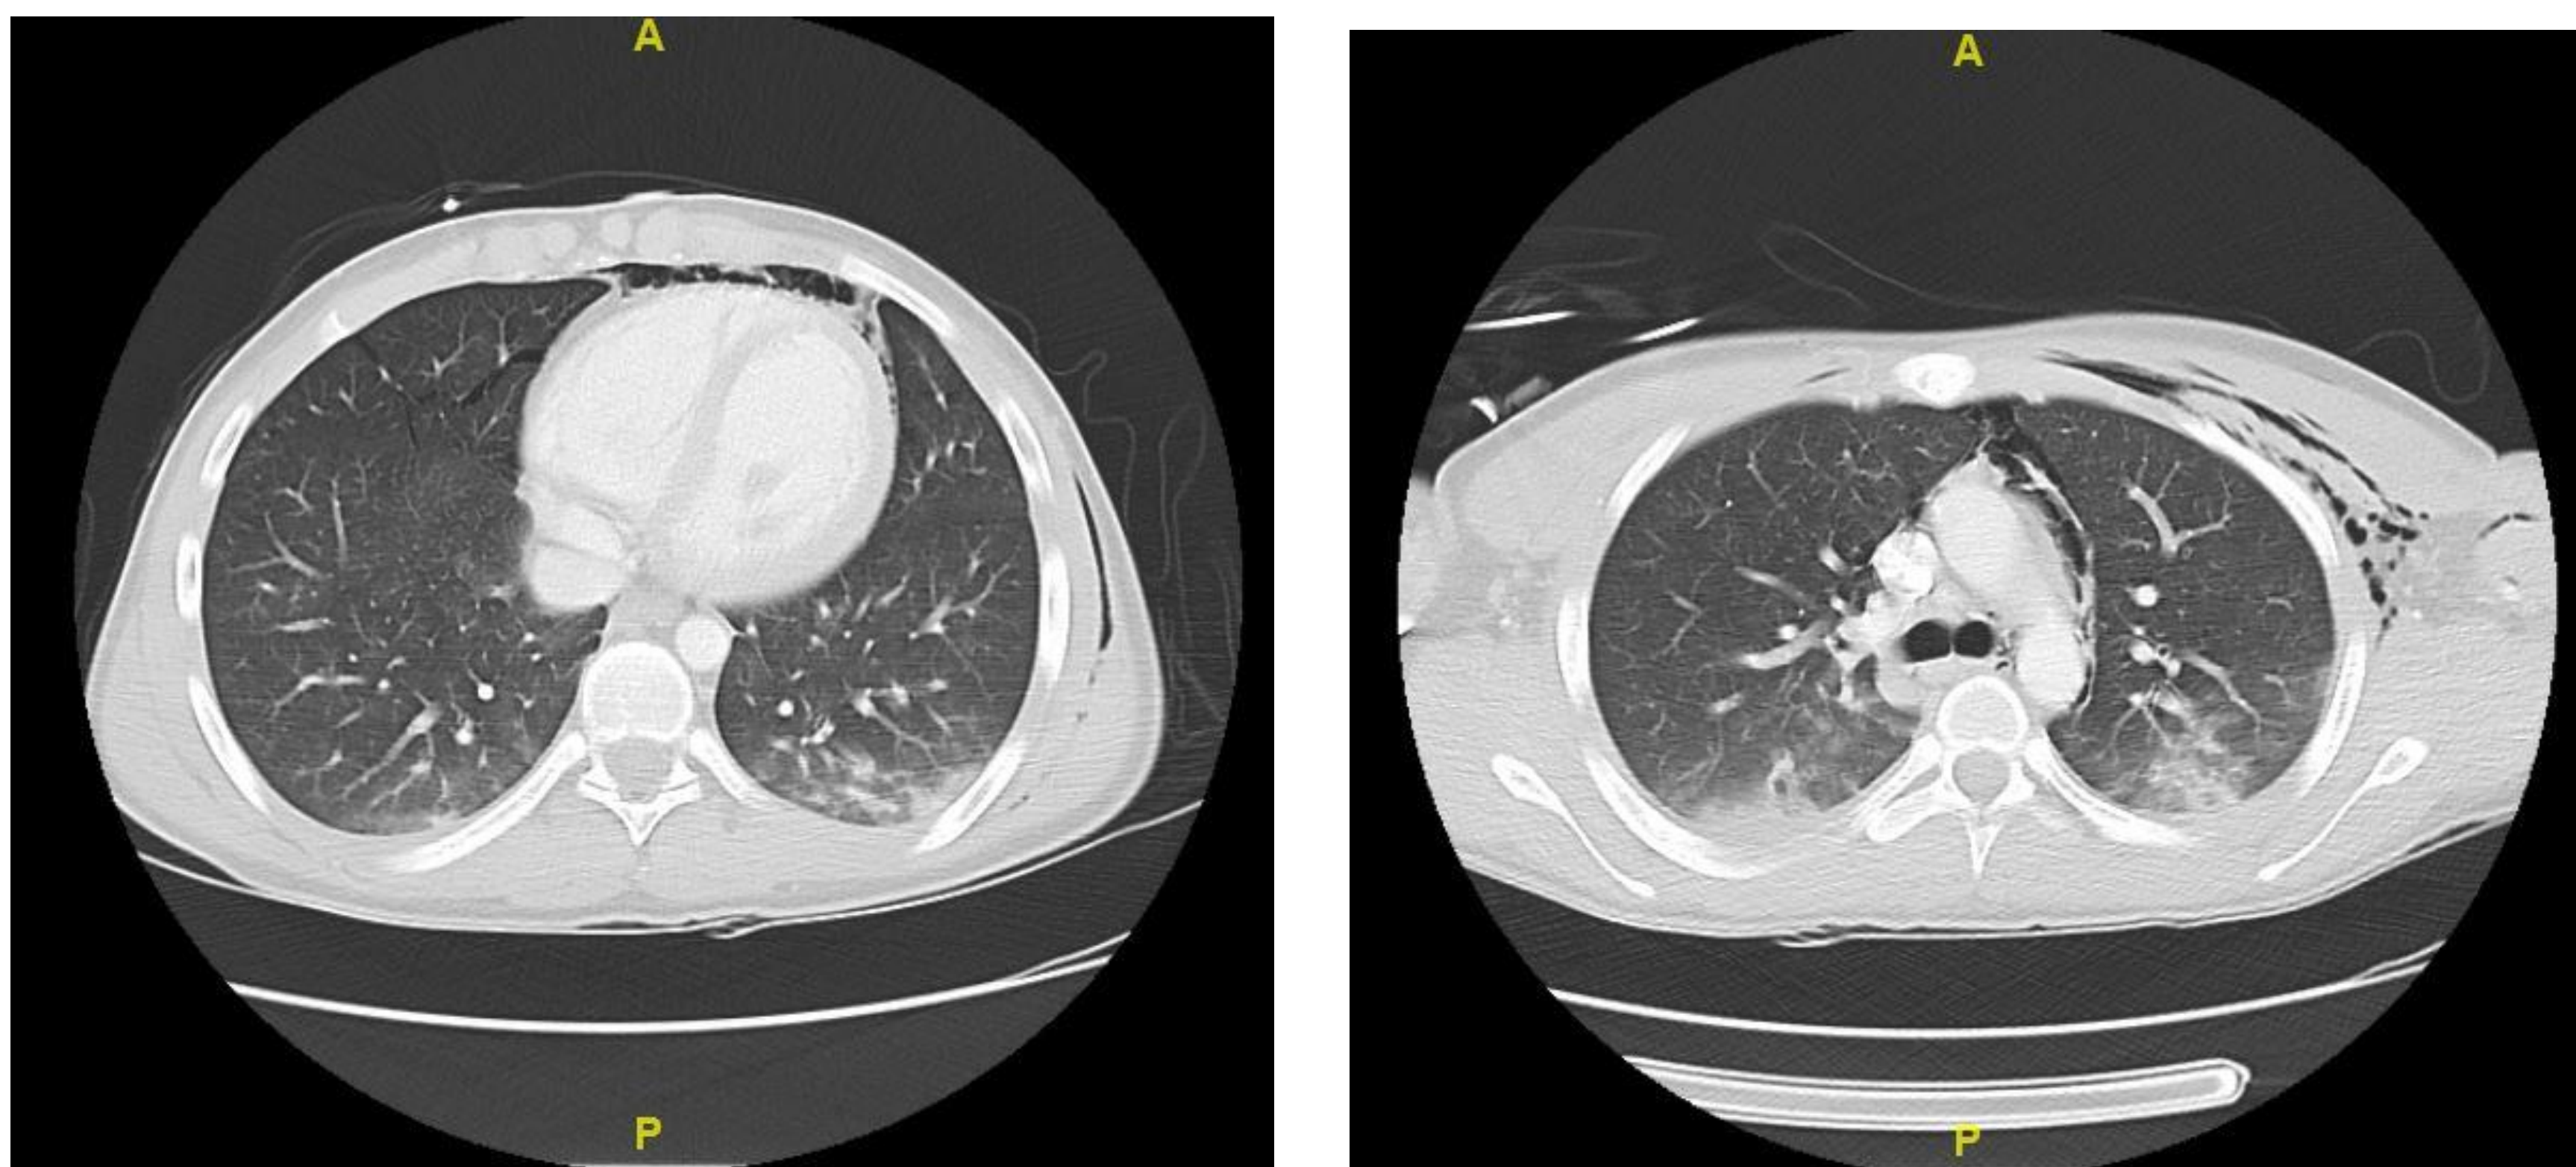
Image stills were created from the CT Chest. Pneumomediastinum present around anterior aspect of pericardium (left) along with anterior aspect of thoracic aorta (right). In addition, subcutaneous emphysema noted on left anterior chest wall (right)
